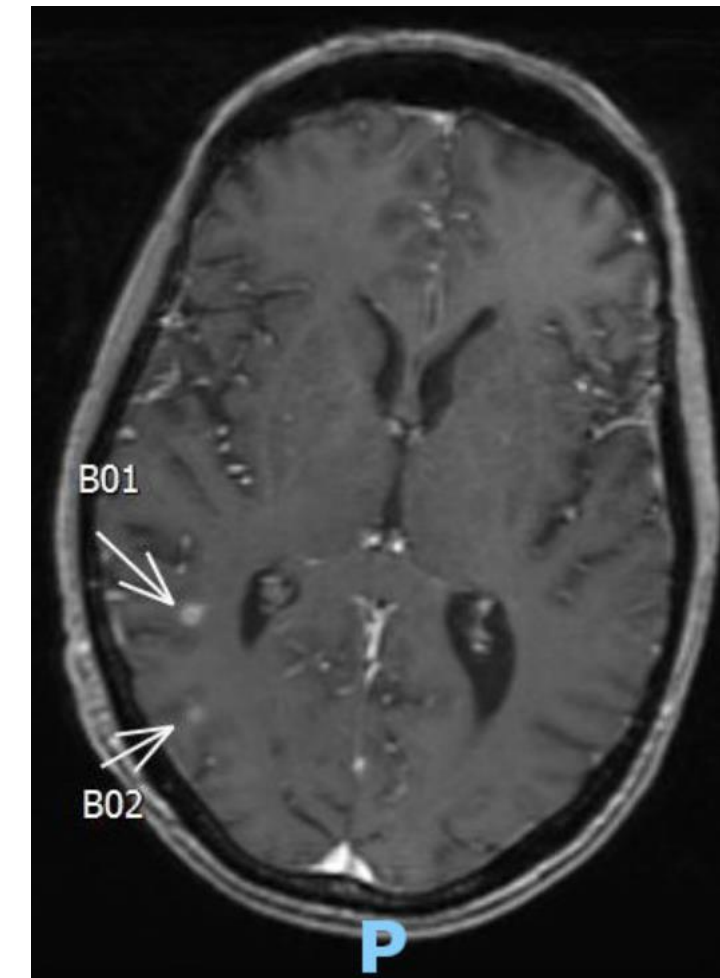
MRI brain noting multiple sub-centimeter foci.
